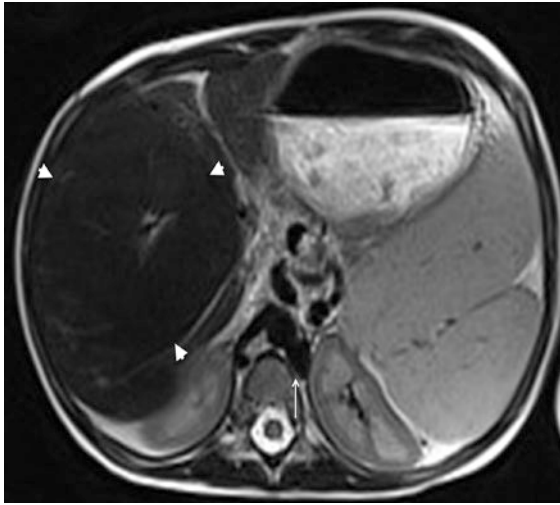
T2W MRI image of a patient with BASM. The liver is cirrhotic with a large central regenerative nodule (central plate hypertrophy, *arrowheads*) and atrophied left lobe and posterior segments of the right lobe. There is polysplenia and interrupted IVC with hemi-azygous continuation (*arrow*)
